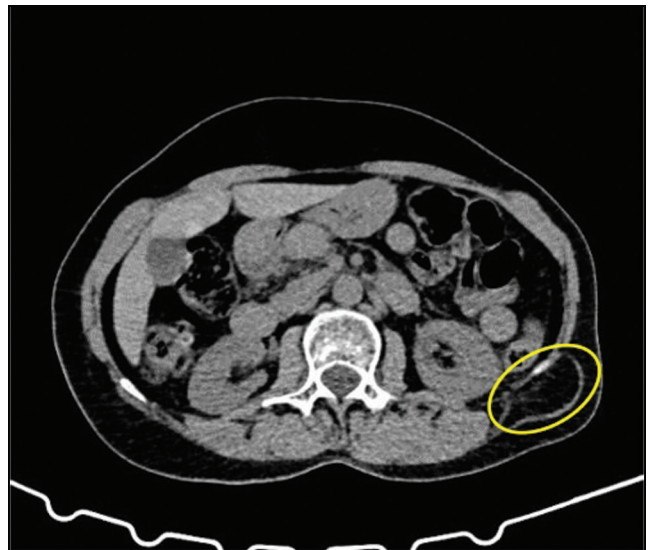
Presence of lumbar hernia in computed tomography (yellow circle)
